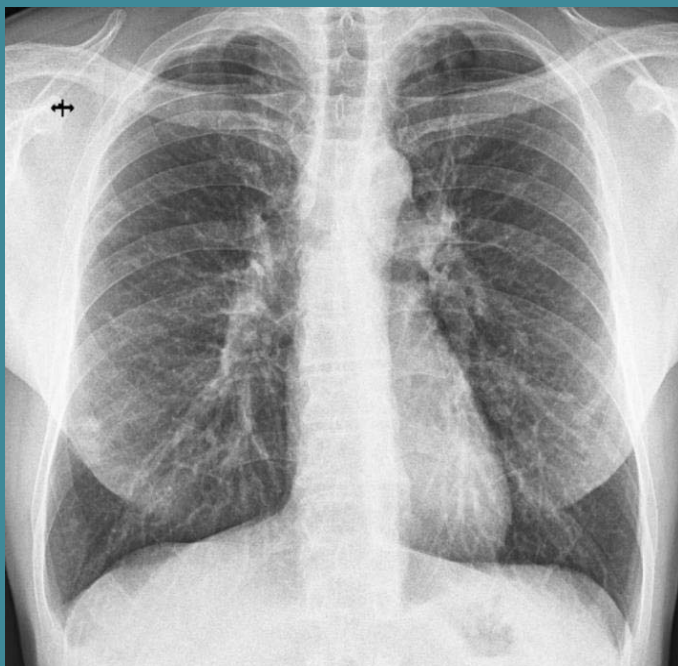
Standard chest X-ray showing bilateral hilar enlargement and multiple diffusely disseminated nodular opacities, bilaterally
